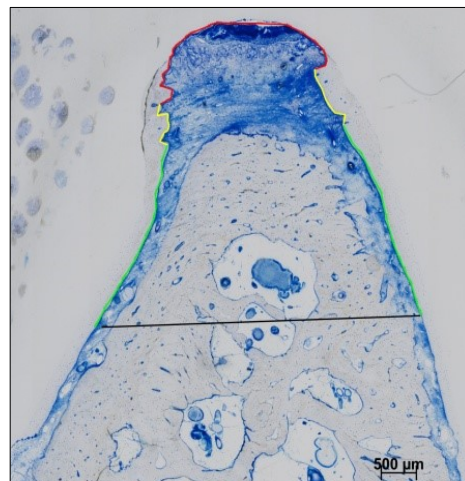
Representation of the different tissues marked in specific colour and measured sections. green: NA, yellow: CTA, red: EA, not in this picture: turquoise: CTA+NC, white: concrement, purple: old attachment.
